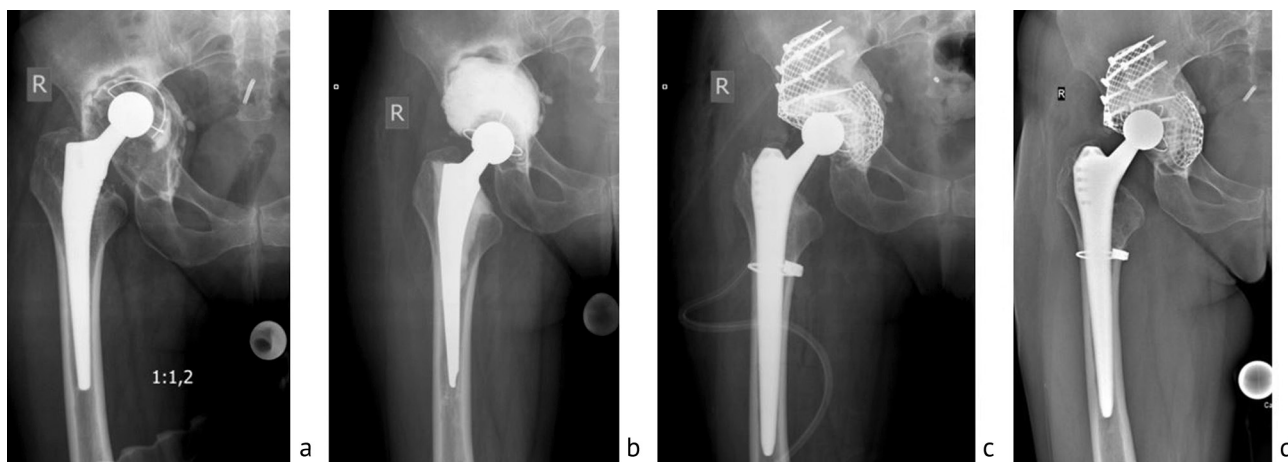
Patient B., 38 years old. Radiographs of the right hip joint at the main stages of treatment: *a* before surgery; *b* after installing a hip joint spacer; *c* after reconstruction using IBG and mesh; *d* at the last follow-up 6.5 years after joint reconstruction
